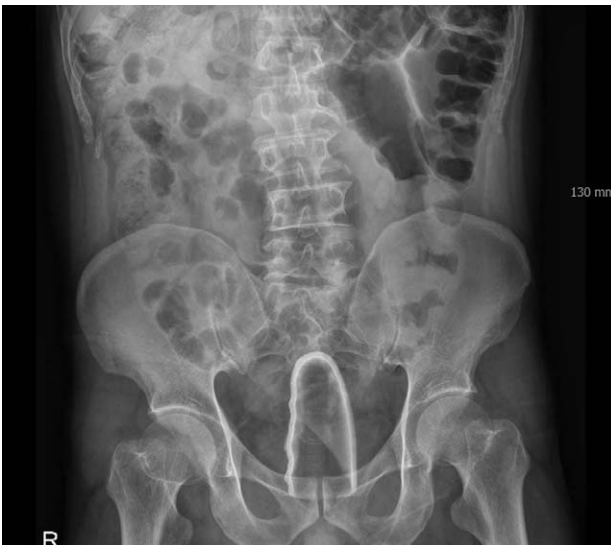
Pelvic X-ray, laboratory beaker in pelvis.
